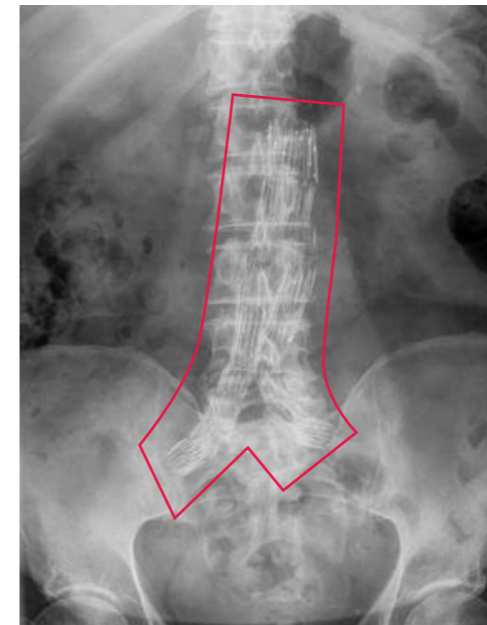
Example of X-Ray image of EVAR with highlighted location
